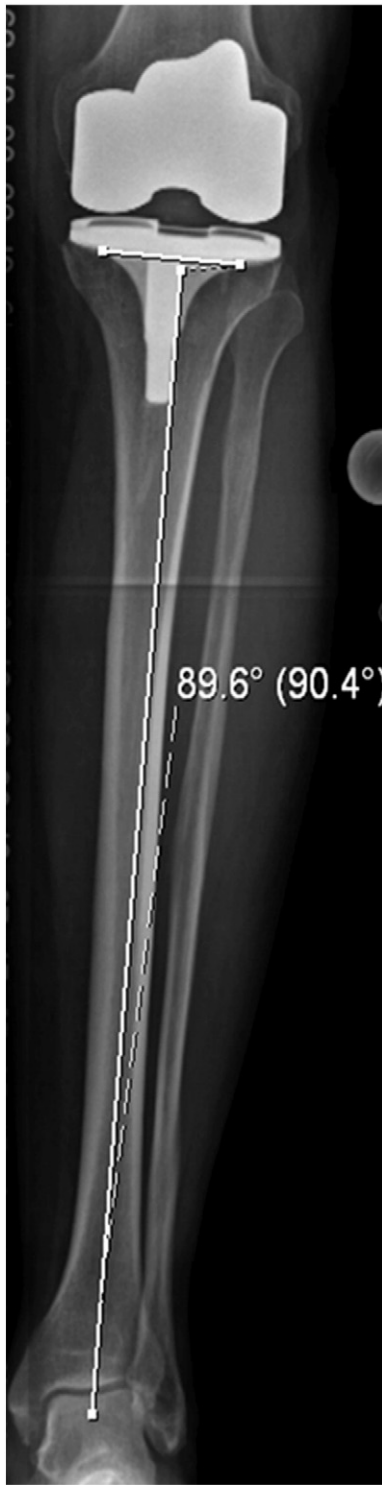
Anteroposterior radiograph demonstrating measurement of the tibial component varus/valgus alignment relative to the coronal mechanical axis. This component was measured to be in 0.4° of valgus.
